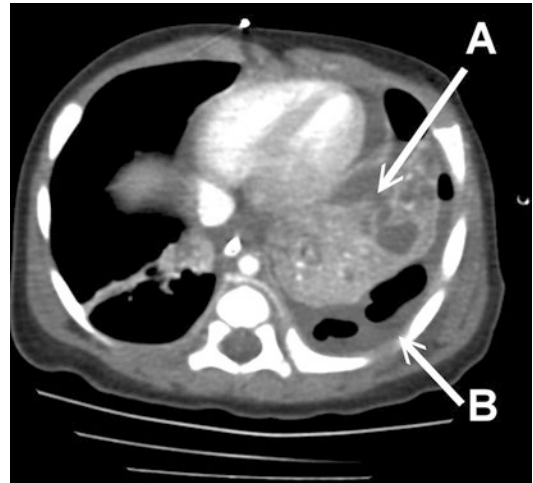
Chest computed tomography of case 2 shows consolidation in the right upper lobe and left lung with (a) abscess and (b) left hydropneumothorax in the left lung
